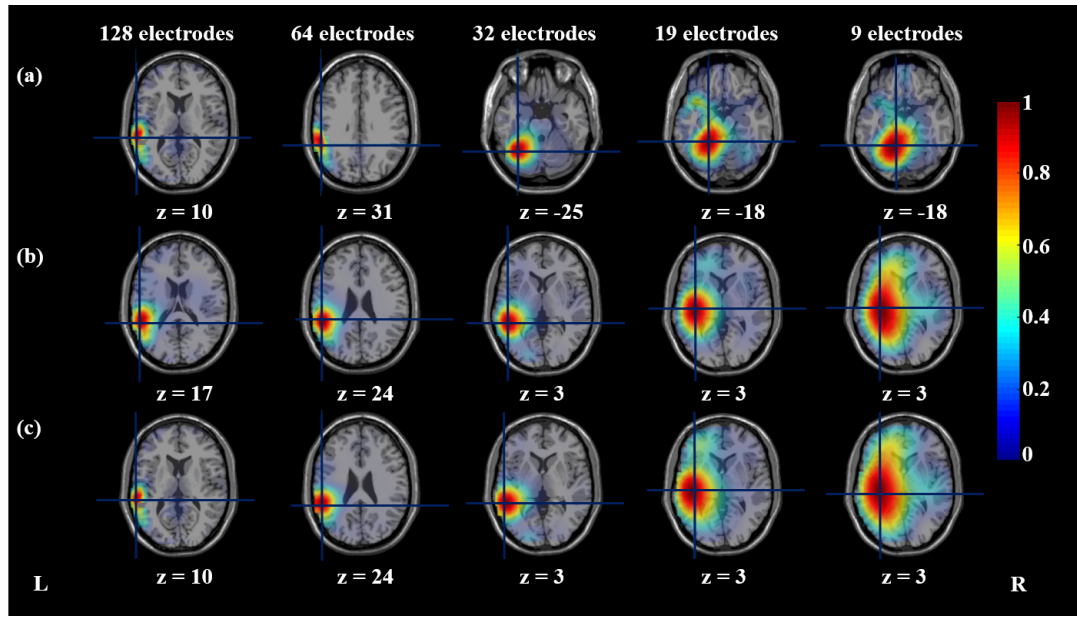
EEG source imaging results via STKF of a non-averaged spike selected from the EEG dataset, which was generated from the left lateral temporal source with  $5 \text{ cm}^2$  source area. STKF results using a gray-matter 3D grid and the classical Laplacian matrix are depicted in (a). Results using a full-brain 3D grid and the classical Laplacian matrix are shown in (b). For the results shown in (c), a full-brain grid and the modified Laplacian matrix were used. The results from the 128-, 64-, 32-, 19-, and 9-electrode datasets are shown in columns 1-5 from the left, respectively. The results are visualized as axial MRI slices at each spike's peak, and the cursor is placed at the maximum of the estimated current density. Additionally the  $z$ -coordinates of the axial slices are shown in MNI coordinates. The source imaging results were visualized using the Fieldtrip software [OFMS11]
